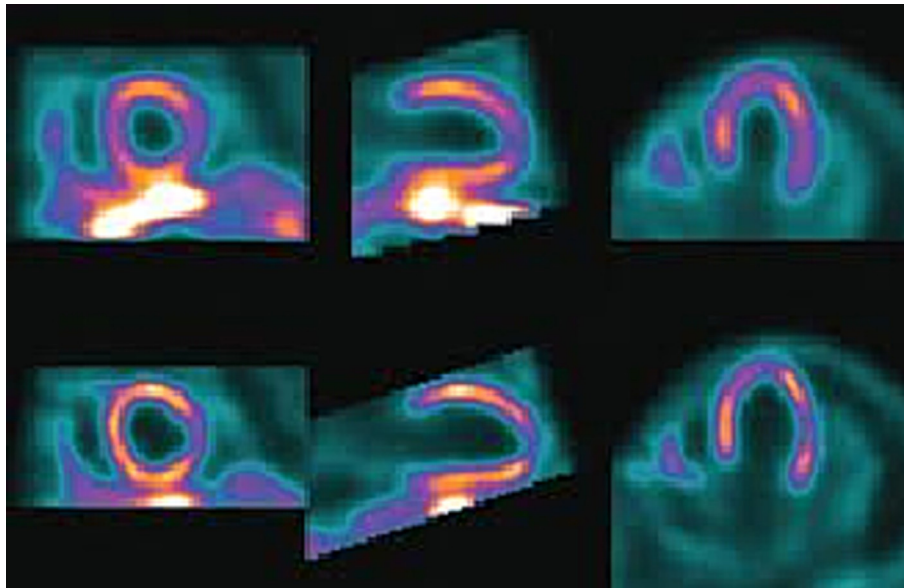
Comparison of 64×64 matrix (top) with 128×128 matrix (bottom) for Philips BrightView SPECT/CT system for a patient with a history of congestive heart failure, hypertension, coronary artery disease and myocardial infarct (Philips, 2010).
